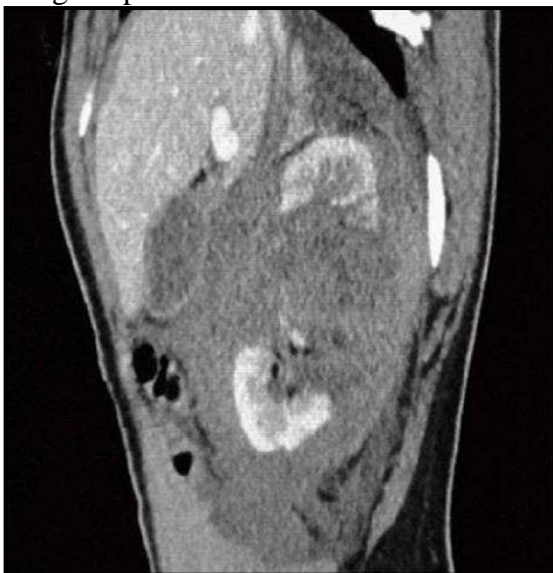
Grade III renal injury. Contrast enhanced computed tomography (CECT) images of a 27- year-old male patient who had a stab injury in the left flank. A: Axial section showing a deep laceration (arrow) reaching up to the hilum; B: Coronal section showing the deep laceration at mid pole with disruption of the para-renal fascia and a large hematoma (star) lateral to it; C: Axial delayed image in excretory phase showed no excreted contrast extravasation (9).
